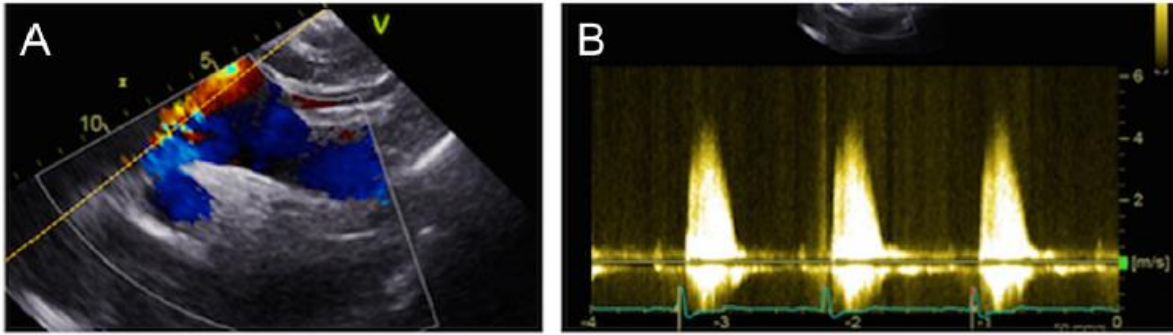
(A) Doppler echo scan of a patient with aortic stenosis - suprasternal view; (B) corresponding Doppler waveform<sup>19</sup>
